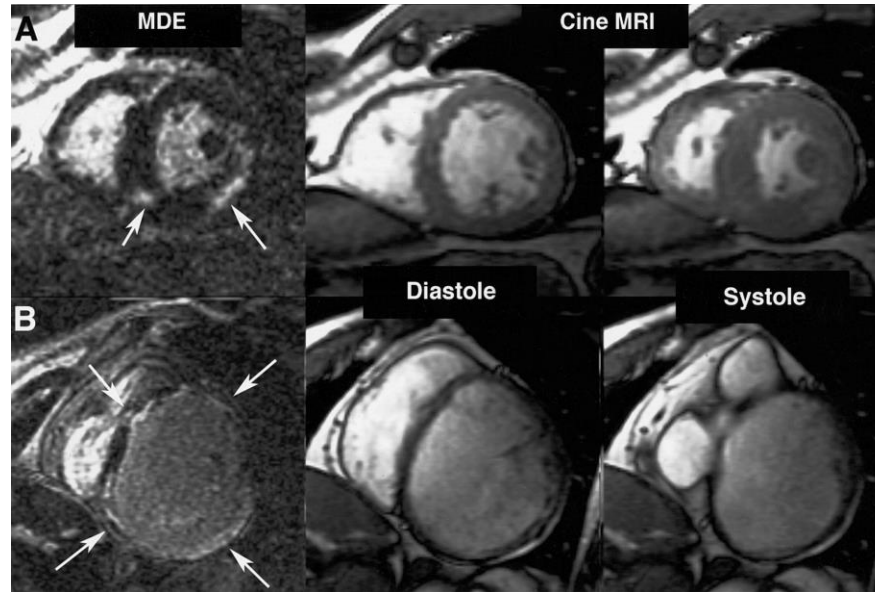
Extent of myocardial fibrosis (MF) (arrows) and left ventricular function. (A) Patient with small area of MF (8.2%) and normal left ventricular ejection fraction (65.5%). (B) Patient with large area of MF (23.8%) and severe left ventricular dysfunction (left ventricular ejection fraction 19.2%). MDE = myocardial delayed enhancement; MRI = magnetic resonance imaging.
